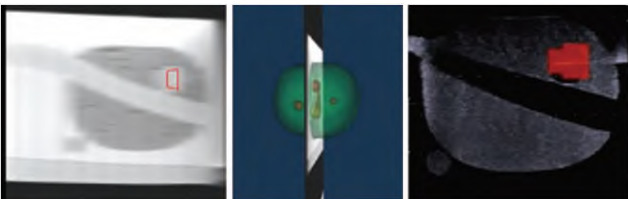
MRI re section images, 3D models and TRUS images in puncture guidance
